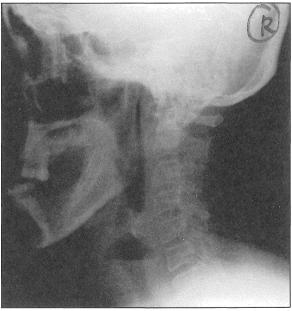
Plain radiograph of the neck (lateral view) showing the well loculated abscess cavity with distinct air fluid level
